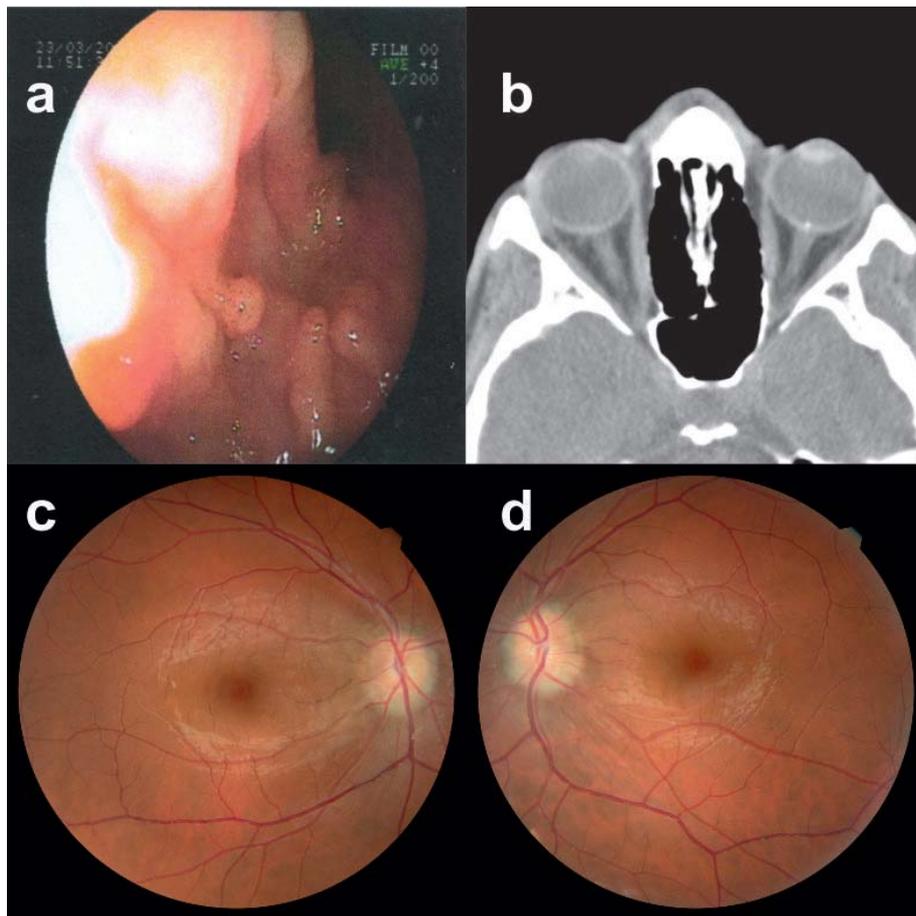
a) Colonoscopy photographs of case 2, b) Axial CT of orbits of case 2 and c, d) Color fundus photographs of case 2.
